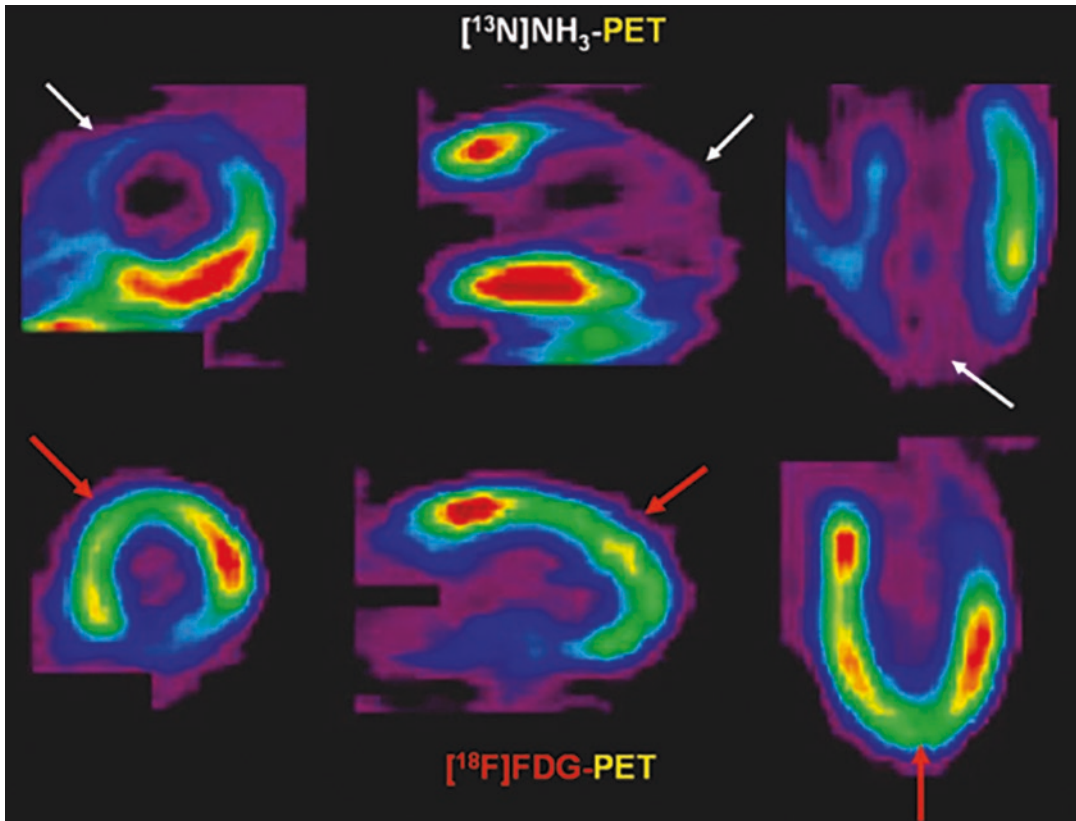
FDG-PET to image myocardial viability. Classic mismatch showing FDG uptake in the areas of decreased myocardial perfusion identified by [^{13}N]NH₃
